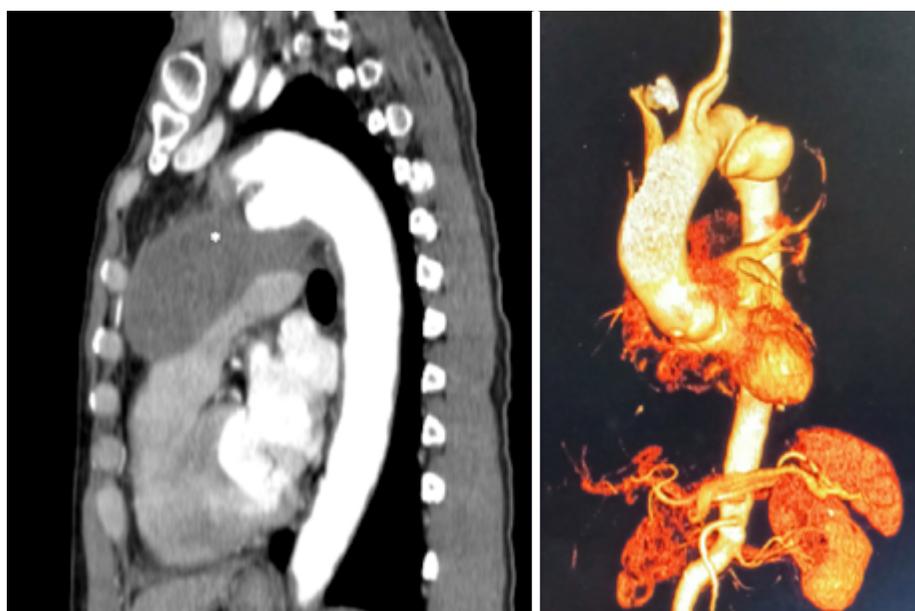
Computed tomographic angiography images of the patient showing a saccular descending thoracic aortic aneurysm (DTAA), including sagittal and oblique sagittal views with three-dimensional (3D) volume reconstruction.
